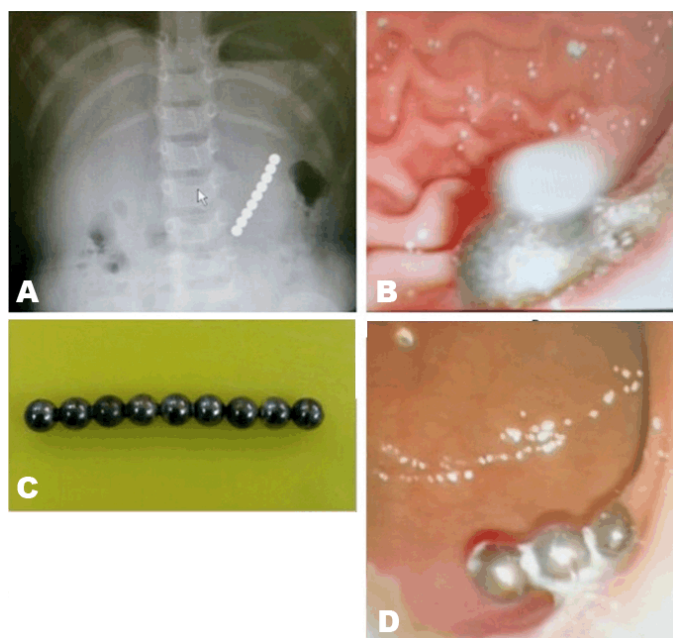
Gastric submucosal perforation following multiple magnet ingestion. Panel (A) Abdominal X-ray examination showing nine opaque foreign bodies with a round shape in the gastric area, (B) Two magnets appeared at the lesser curvature, (C) Ingested magnets, and (D) Submucosal gastric pouch in which the magnetic bead were lodged.
